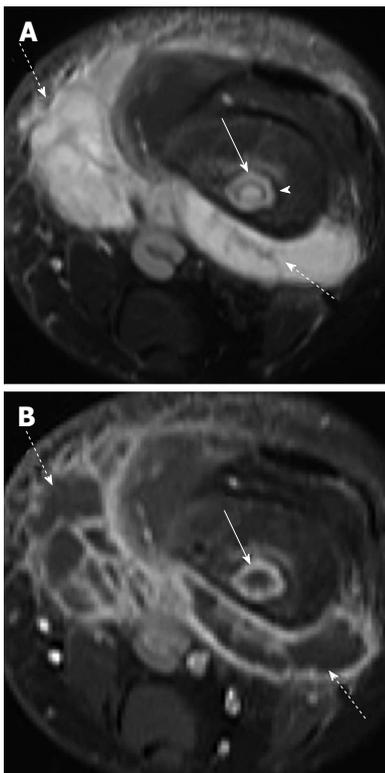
Osteomyelitis with intraosseous and soft tissue abscess secondary to methicillin-resistant *Staphylococcus aureus* infection. A: Axial T2-weighted fat suppressed image shows intraosseous abscess cavity (solid arrow) with rim of surrounding edema and large surrounding soft tissue fluid collection (dashed arrow). Note T2 hypointense rim (arrowhead) forming the “double-line” sign; B: Axial T1-weighted post-contrast image shows peripheral enhancement associated with the intraosseous abscess (solid arrow) and soft tissue abscesses (dashed arrows).
